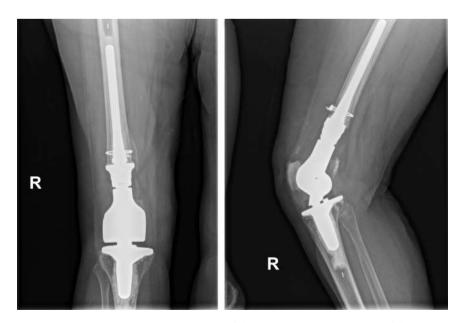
Anteroposterior and lateral radiograph of the right knee at 1-year postoperative follow-up.
